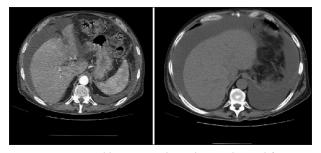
A 67-year-old man was admitted to our hospital for severe necrotizing pancreatitis with pancreatic ascites and pleural effusion. Contrast-enhanced computed tomography of the chest, abdomen, and pelvis showing diffuse pancreatic ascites (axial view)
